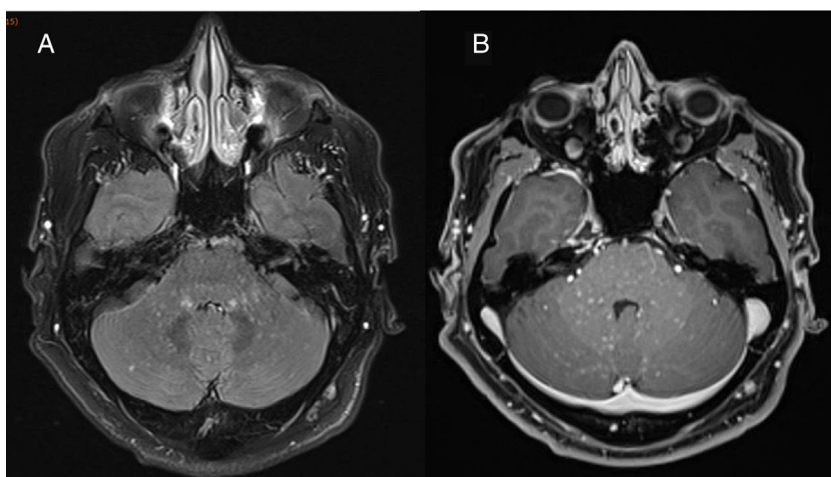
Axial T2-weighted FLAIR brain MRI scan obtained in a 3T scanner at the time of diagnosis, before treatment onset. A) The image shows numerous hyperintense punctiform foci measuring < 3 mm in diameter (“salt and pepper sign”), predominantly in the infratentorial region (particularly affecting the middle cerebellar peduncles and pons), with no perilesional mass effect. B) Homogeneous gadolinium enhancement in all punctiform foci.
